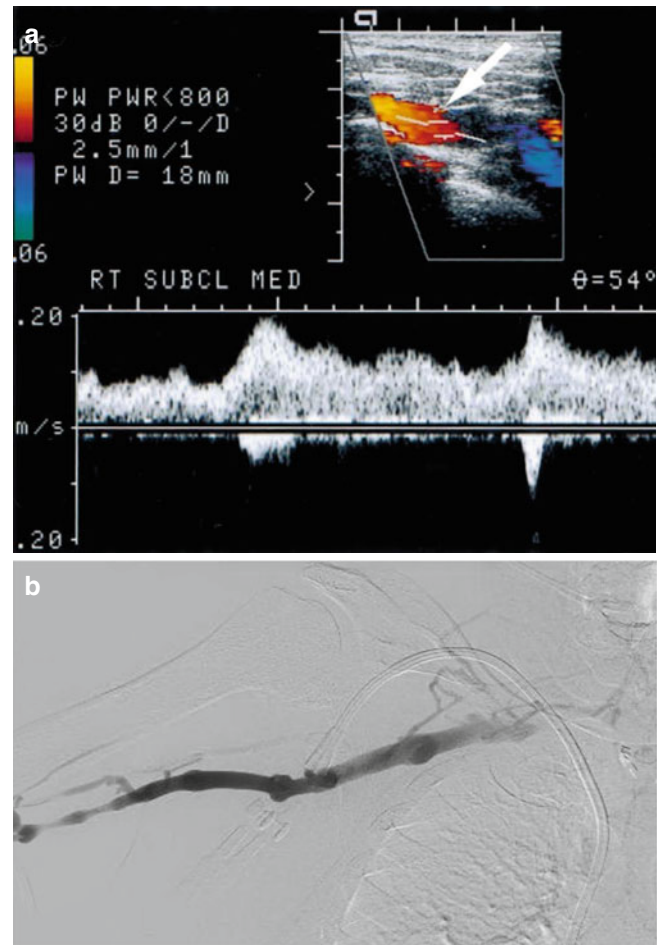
Duplex detection of central venous stenosis. Preoperative US mapping in a 49-year-old man. (a) Longitudinal US scan of a patent subclavian vein (*arrow*). The Doppler waveform shows abnormal respiratory phasicity, with monophasic flow that does not decrease to baseline with inspiration. These findings are suggestive of central brachiocephalic venous or superior vena cava stenosis or occlusion. (b) Corresponding anteroposterior venogram shows 50% stenosis of the brachiocephalic vein (*arrowheads*) compared with the normal-caliber subclavian vein (*arrows*). (used with permission from 18)
